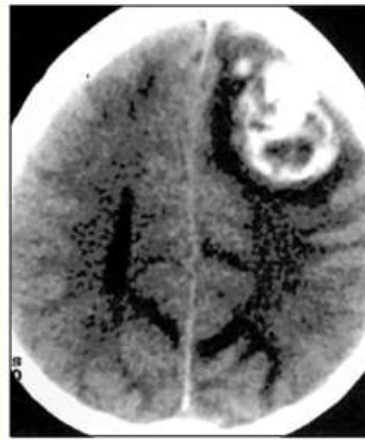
CT scan shows a well-defined heterogeneous hemorrhage in the left frontal lobe, with adjacent vasogenic edema.
